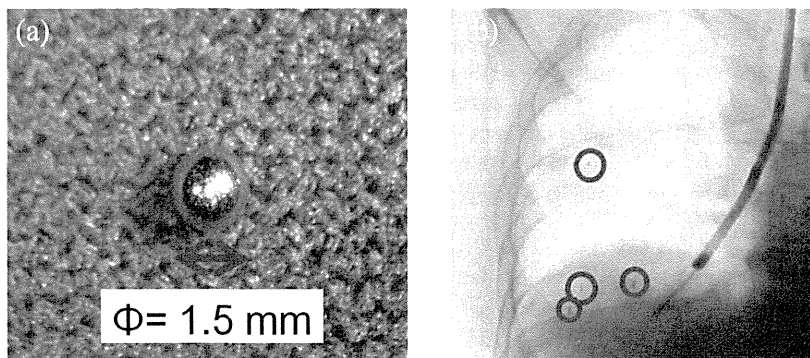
Photographs of (a) a gold marker with a diameter of 1.5 mm (courtesy of Olympus Medical Systems Corporation, Japan) and (b) an X-ray fluoroscopy image of four gold markers implanted in a lung. The photon mass attenuation coefficient of gold markers is much larger than that of normal tissue.
